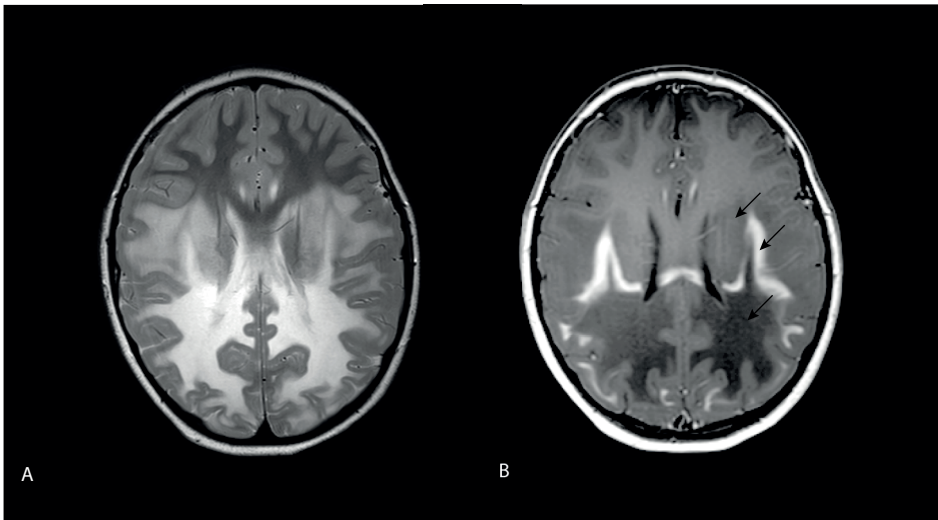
Structural MRI in a boy with cerebral ALD
